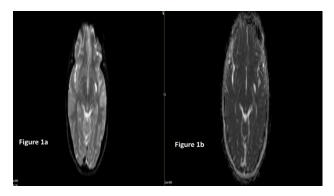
MRI brain: Axial: FLAIR, SWAN, DW/ADC (A), and T1WI pre-and post-contrast (B).
